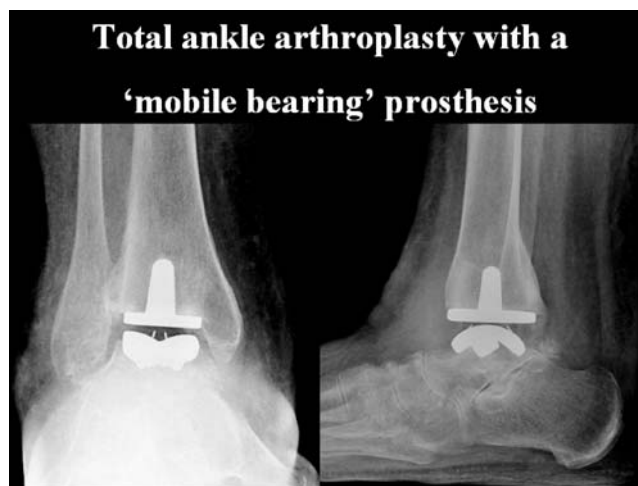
Radiographic appearance of a 'mobile-bearing' ankle replacement.
